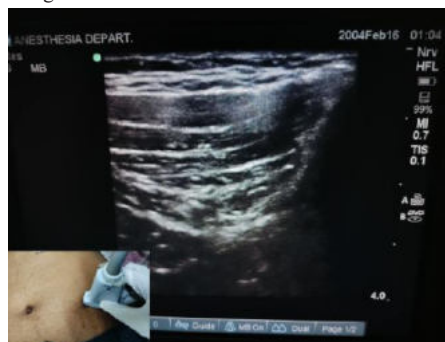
(A) shows ilioinguinal and iliohypogastric nerve with ultrasonography probe placement.
